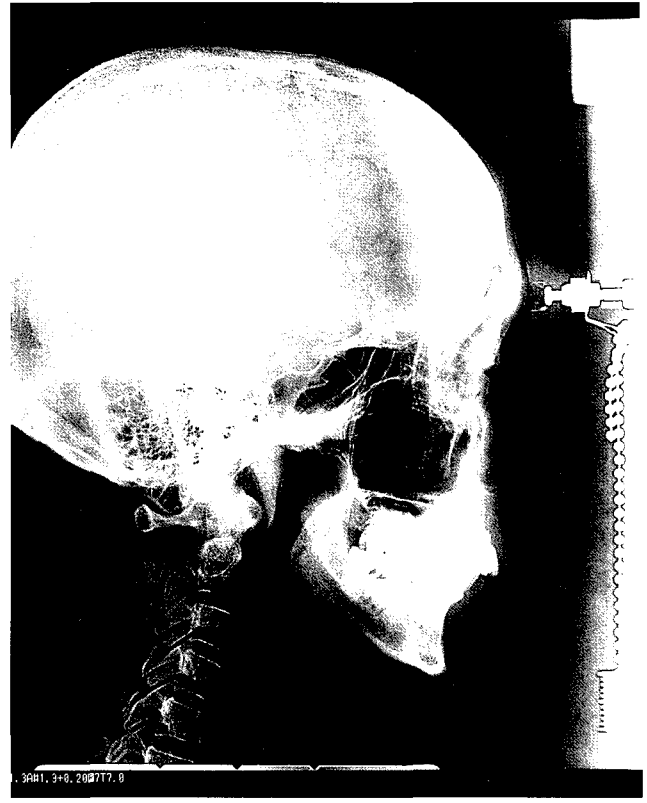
M3 Digital lateral cephalometric radiograph is seen.
